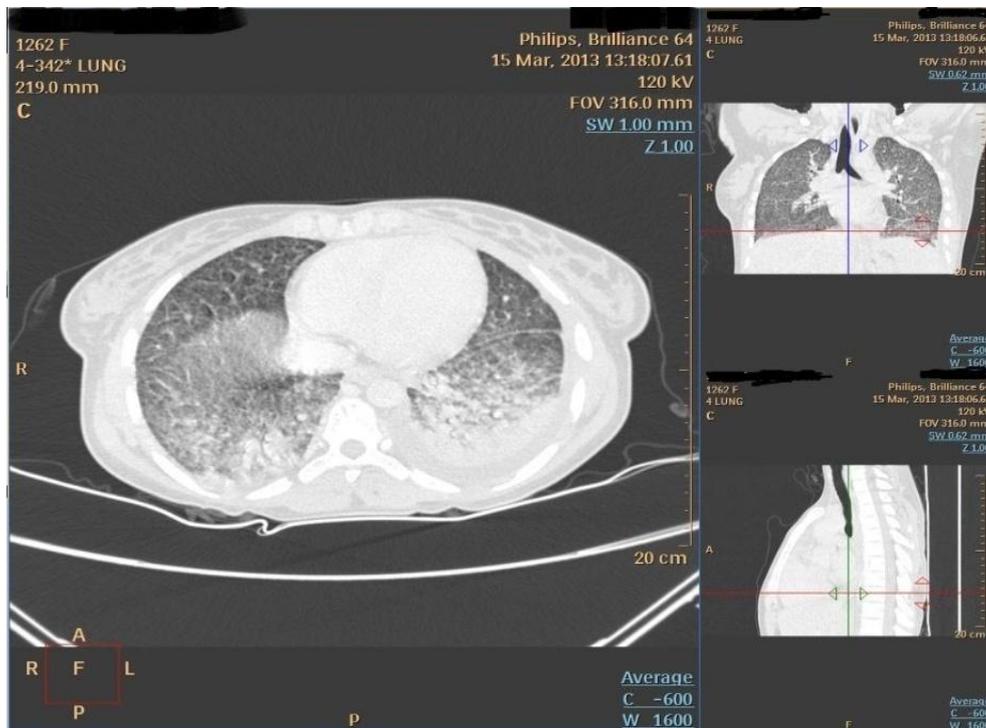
HRCT film showing chest in coronal section with septal thickening and miliary nodules
